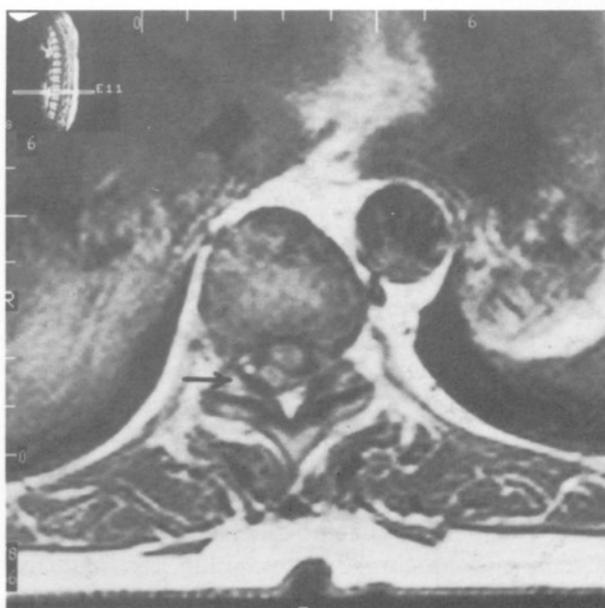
a,b: Sagittal (a) and Axial (b) T1-weighted magnetic resonance images. An isointense postero-lateral extradural mass obliterating the subarachnoid space is seen extending from Th 9 to Th 10 (arrows).
